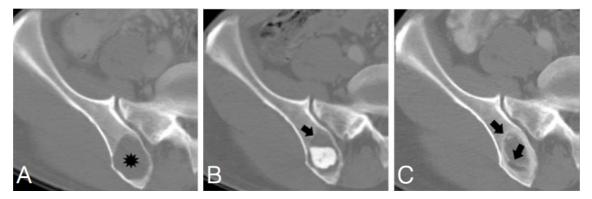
Calcium sulphate ceramic bone graft substitute used for joint repair in a 42-year-old man. Panel A: Preprocedural axial CT image shows a unicameral bone cyst (*) in the right posterior ilium at the level of the superior sacroiliac joint. Panel B: Axial CT image, obtained 1 month after graft placement, shows partial resorption of the graft material (arrow). Panel C: Axial CT image, obtained 2 years after graft placement, shows complete resorption of the graft material and minimal ingrowth of bone (arrows). Figure and legend are adaptations from reference 80.
